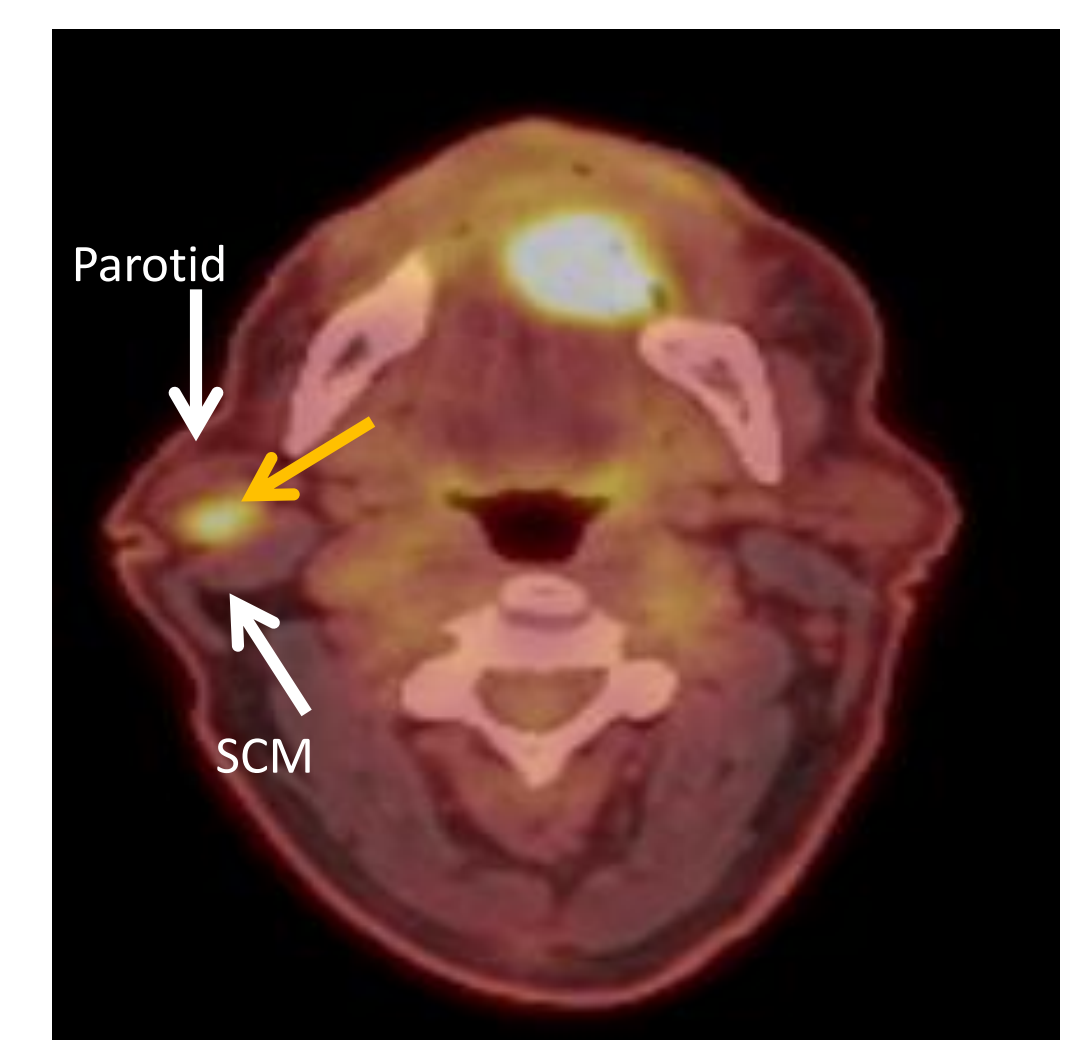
PET-CT demonstrating right parotid lesion (SUV 6.6).
